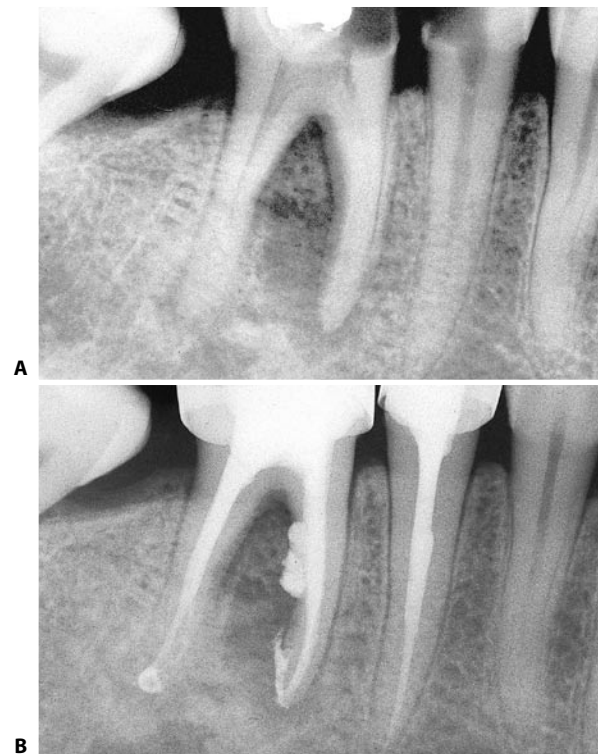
Neglecting to apply the anticurvature filing method leads as a consequence to excessive thinning of the root and perforation or stripping. A. Preoperative radiograph. Note the thinness of the mesial root and its slight curvature. B. Postoperative radiograph. The result of the stripping is evident.
